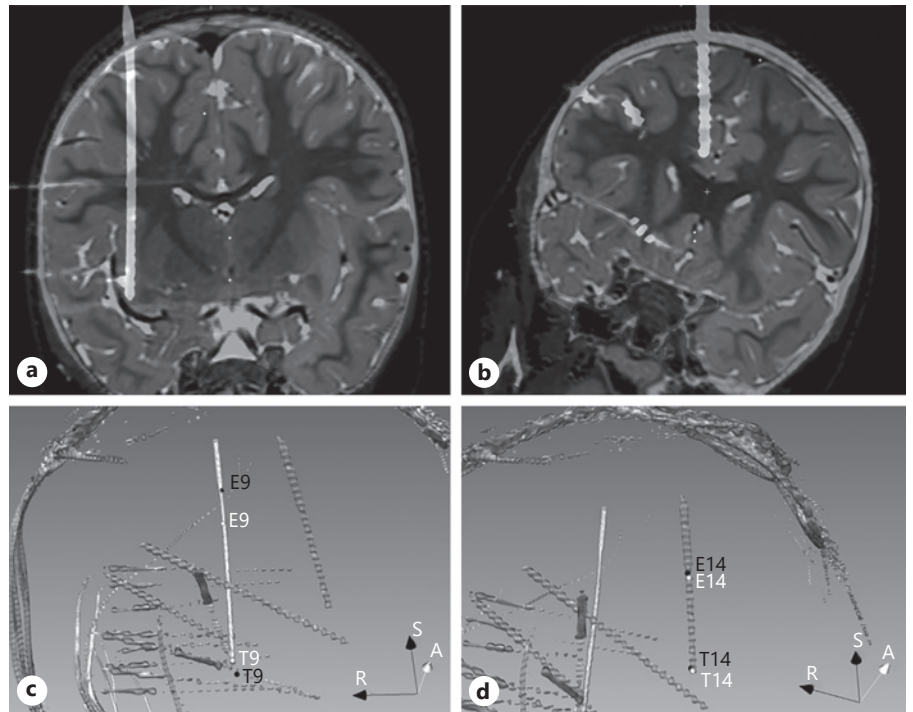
a, b Two of the 15 electrodes targeting posterior insula and anterior cingulate implanted in our patient. c, d 3D view in slicer of the segmented postoperative CT showing the 2 specified trajectories, where the original (black) and automatically detected (white) entry and target locations are marked.
